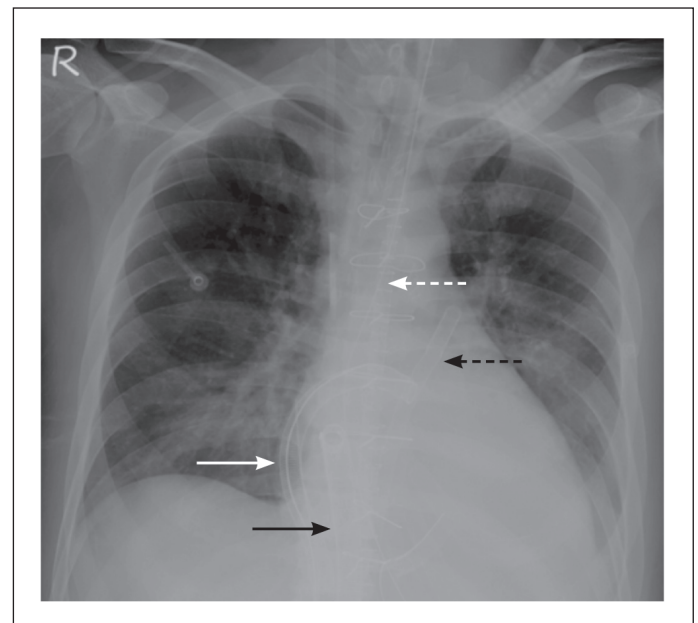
The chest plain film demonstrates the L-VAD inflow tube from the right superior pulmonary vein (solid white arrow), outflow tube into the ascending aorta (dotted white arrow), R-VAD inflow tube from the right atrium (solid black arrow), and outflow tube into the pulmonary artery (dotted black arrow).
